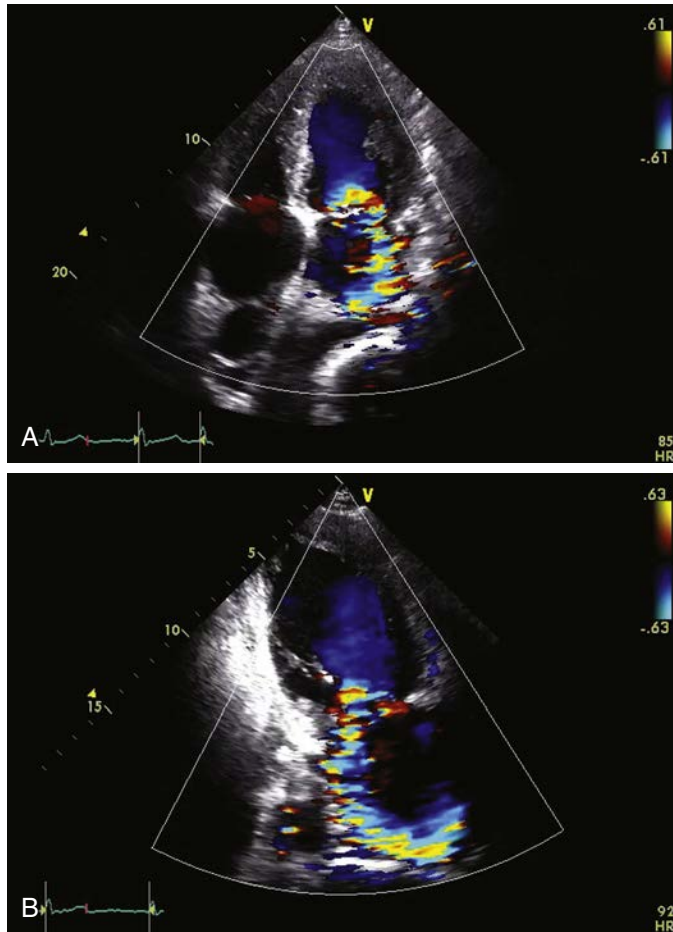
Mitral regurgitation (MR). MR due to impaired mitral leaflet coaptation with relatively normal mitral apparatus (leaflets and chordae). Apical four-chamber (A) and three-chamber (B) views show left ventricular (LV) dilation and akinesia of the inferolateral LV wall involving the posteromedial papillary muscle.
